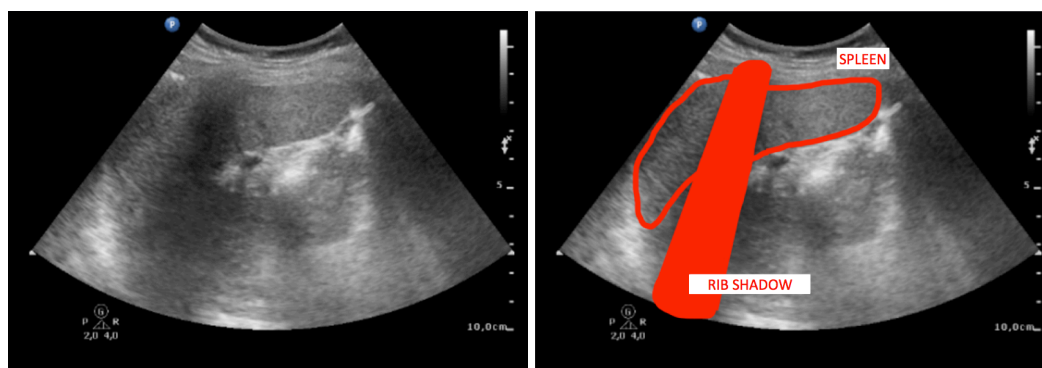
Ultrasonic image of the spleen showing a significant acoustic shadowing caused by a rib.
